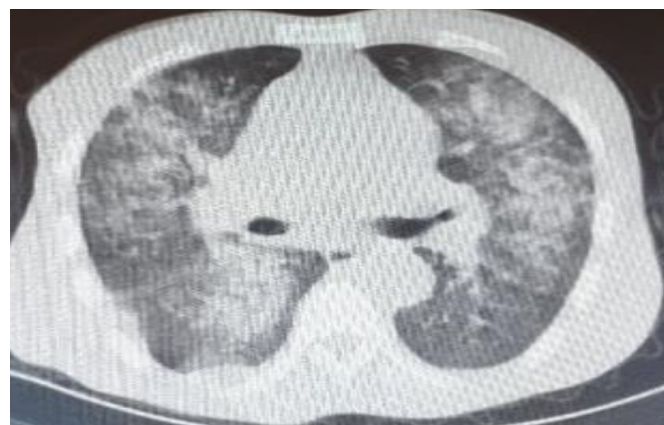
Chest computed tomography at emergency department admission
